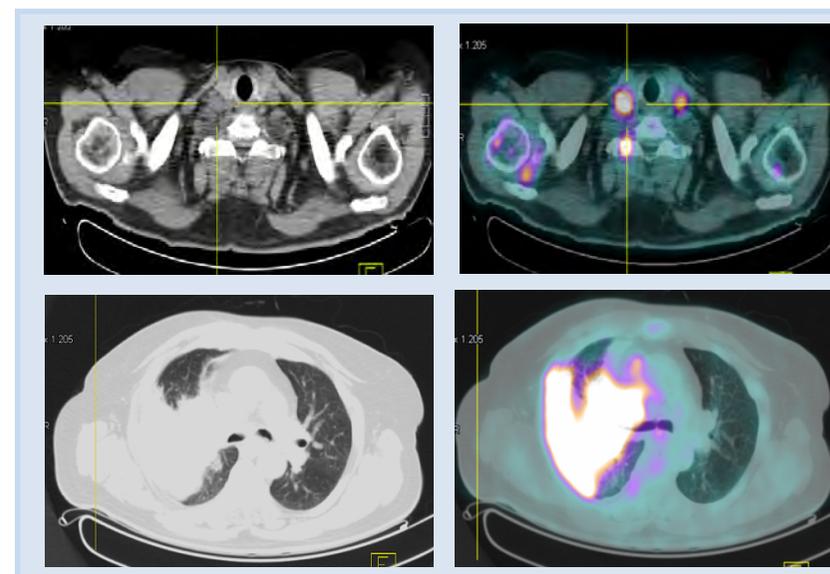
Image comparison of chest CT (left) and PET/CT (right) allowing the definition of hyperuptake areas (adenopathy and infiltrating tumor masses). Images provided by Dr. Renato Salguero, Oncology, Hospital Morales Meseguer. Murcia.
